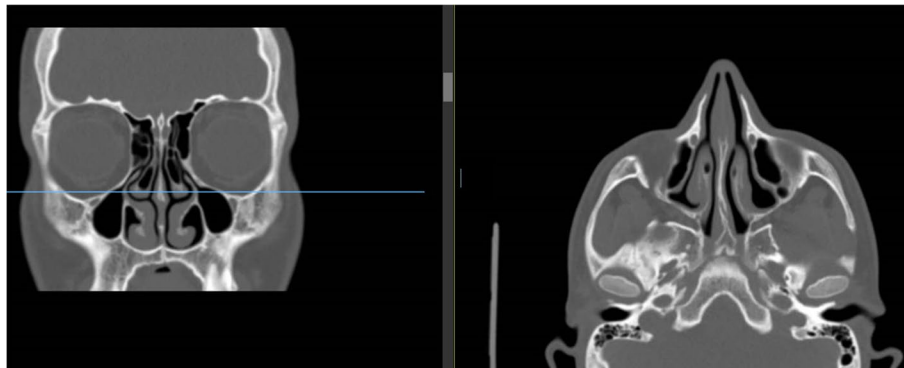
CT shows small maxillary and normally appeared uncinate process
